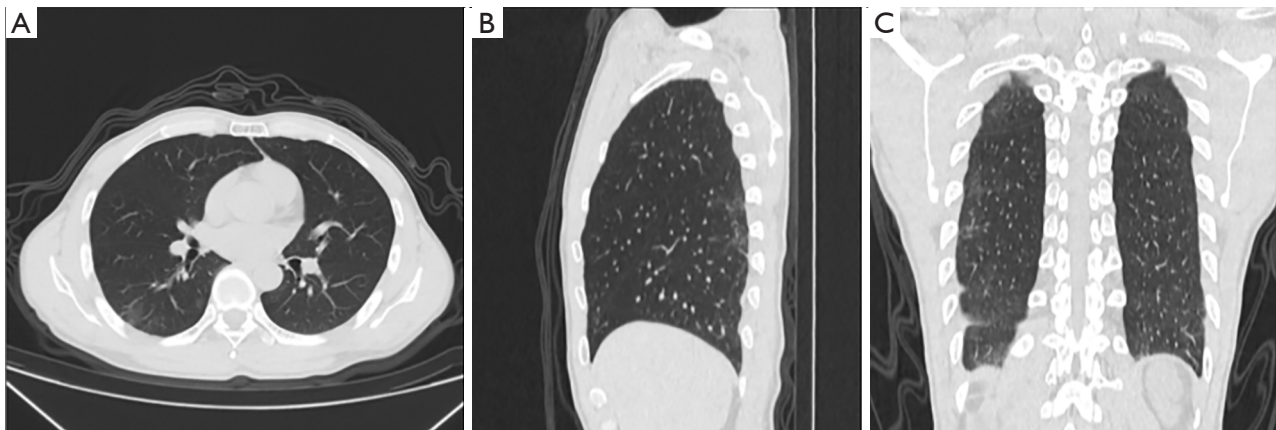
An early case of COVID-19, who manifests ground glass shadow under the pleura of the right lower lung on CT (pictures from the mobile cabin CT of Wuhan Optics Valley mobile cabin hospital).
